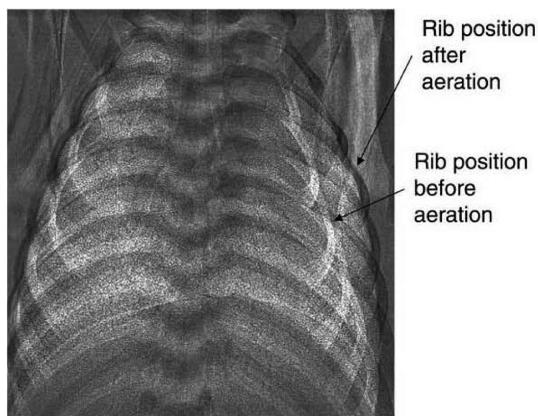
Phase-contrast X-ray imaging showing rib positions before and after lung aeration. The ribs are positioned more horizontally and displaced laterally after lung aeration, indicating a substantially increased thoracic volume caused by the increase in air volume (without the loss of liquid, which has accumulated in interstitium)
